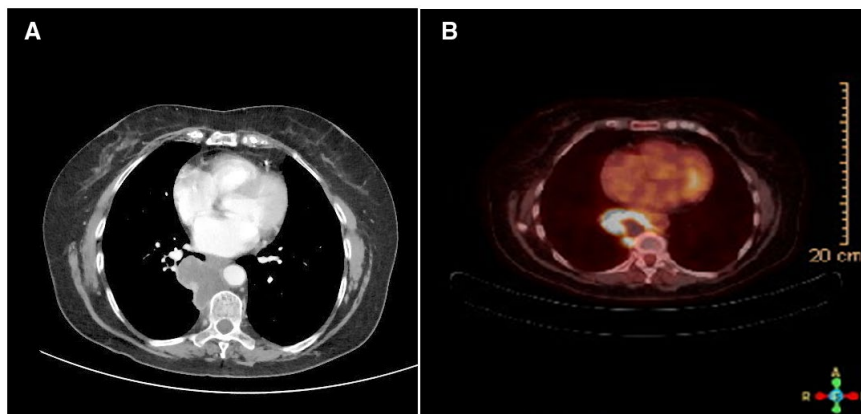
(A) Computed Tomography and (B) Positron Emission Tomography Scan Images at Presentation Showing the Central Mass With Mediastinal Invasion.
